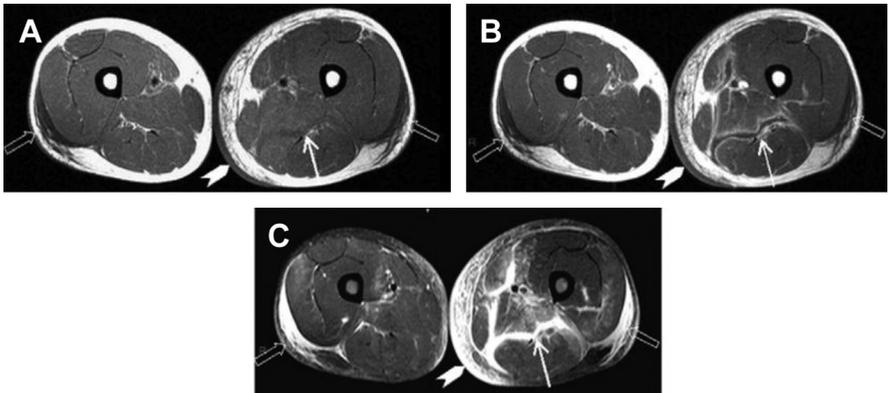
MRI findings for a patient with necrotizing fasciitis and myositis: axial sections of the left thigh demonstrating increased soft tissue enhancement and gas in the soft tissues. T1 images (A) before and (B) after contrast injection where thick white arrows show thickening of skin and subcutaneous fat infiltration and with (C) Short T1 Inversion Recovery (STIR) sequence where thin white arrows show thickening of the deep intermuscular fasciae and hollow arrows show stasis edema. (Reproduced from Malghem J, Lecouvet FE, Omoumi P, et al. Necrotizing fasciitis: contribution and limitations of diagnostic imaging. *Joint Bone Spine* 2013;80(2):146–54; with permission. Copyright © 2013.)
